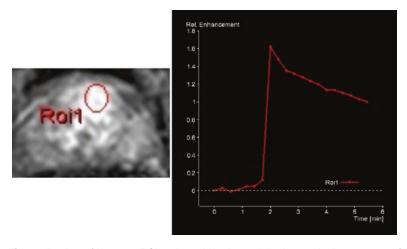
Region of interest (ROI) selected by the radiologist, enclosing an area of the largest enhancement and the corresponding enhancement pattern, of the locations within the ROI, with time (TIC). (This facility is provided by the MRI machine vendor)
